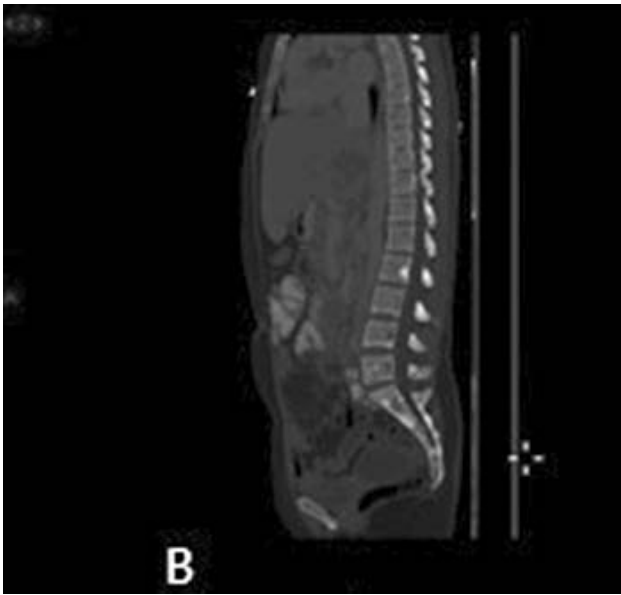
Bony lesions on CT scan
